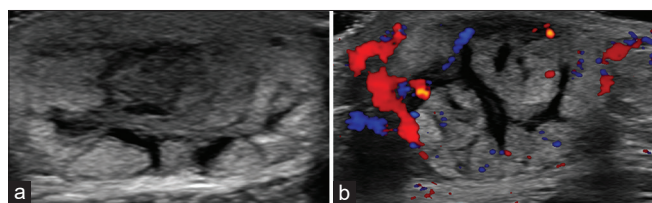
Ultrasound images of the subcutaneous left lateral chest wall lesion (a). Ultrasound images with color Doppler of a newly developed palpable subcutaneous lesion in the right upper chest wall demonstrating the internal vascularity present in all lesions (b)
